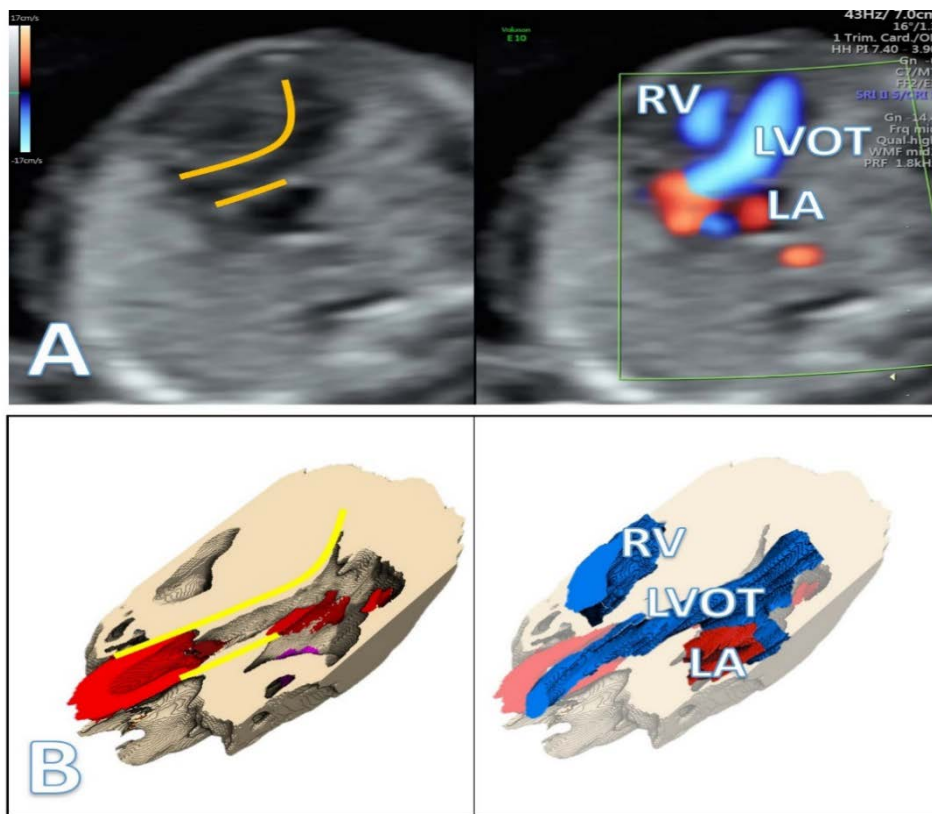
Evaluation of the left ventricular outflow tract. A. Ultrasound duplex mode showing the septo-aortic continuity in grey mode (left, marked by yellow lines) and normal left ventricular outflow tract. B. Three-dimensional representation identifying the septo-aortic continuity (left, marked by yellow lines) and visual representation of the cavities and vessels volume resembling the Doppler examination (right) RV: right ventricle; LVOT: left ventricle outflow tract; LA: left atrium
